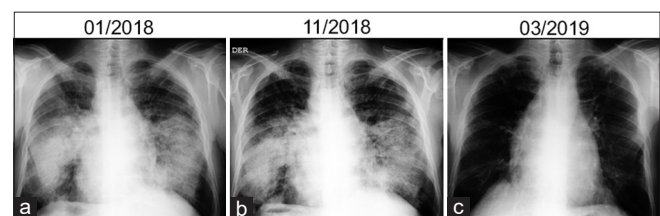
Chest X-rays were used to evaluate the patient's evolution. (a) Chest X-ray on January 2018 shows a bilateral perihilar and infrahilar ground-glass opacity. (b) Two months after adjusting the medication, a similar pattern was observed (November 2018). (c) Six months later, the lungs appeared cleared which correlated with the clinical evolution (March 2019)
